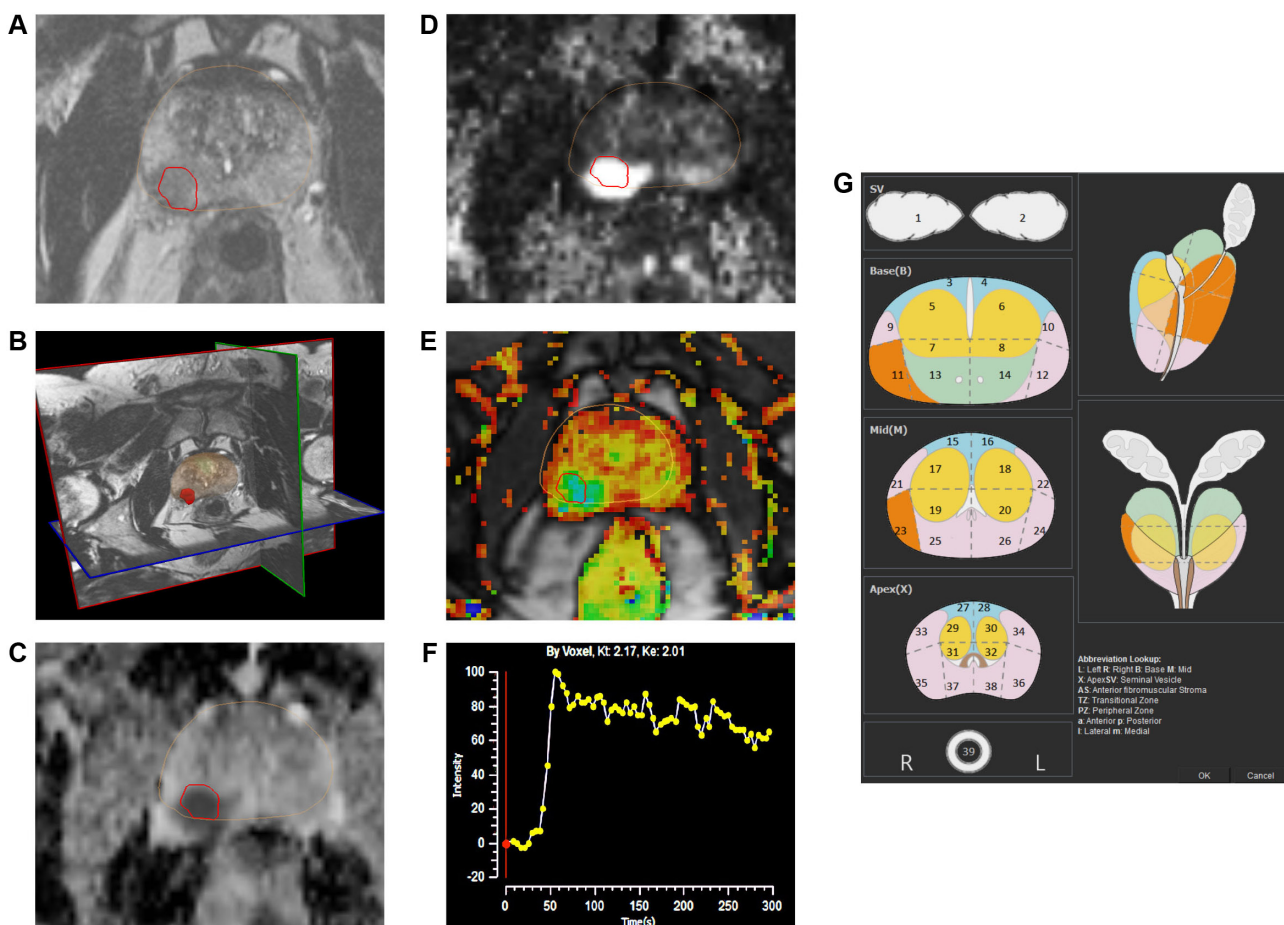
The mpMRI depiction of right posterolateral lesion: (A) axial T2-weighted image with lesion in red outline, (B) 3D T2-weighted view of prostate contour (brown) and lesion (red), (C) ADC image with lesion in red outline, (D) computed high b -value = 2000 seconds/mm² image with lesion in red outline, (E) dynamic contrast-enhanced pharmacokinetic map with lesion in red outline, (F) average time-signal intensity curve plot of the lesion, and (G) PIRADS version 2 location of lesion (orange).
